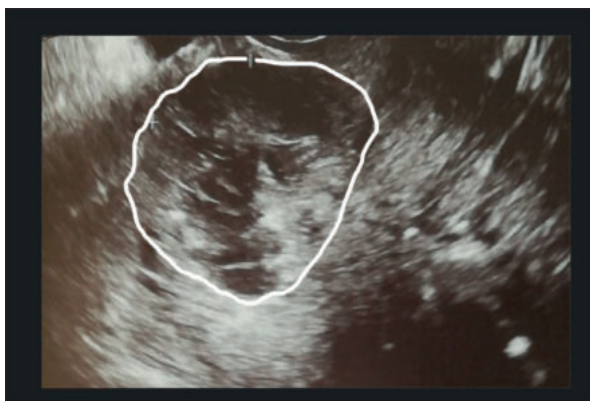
Ultrasound finding in the uterine cavity.
